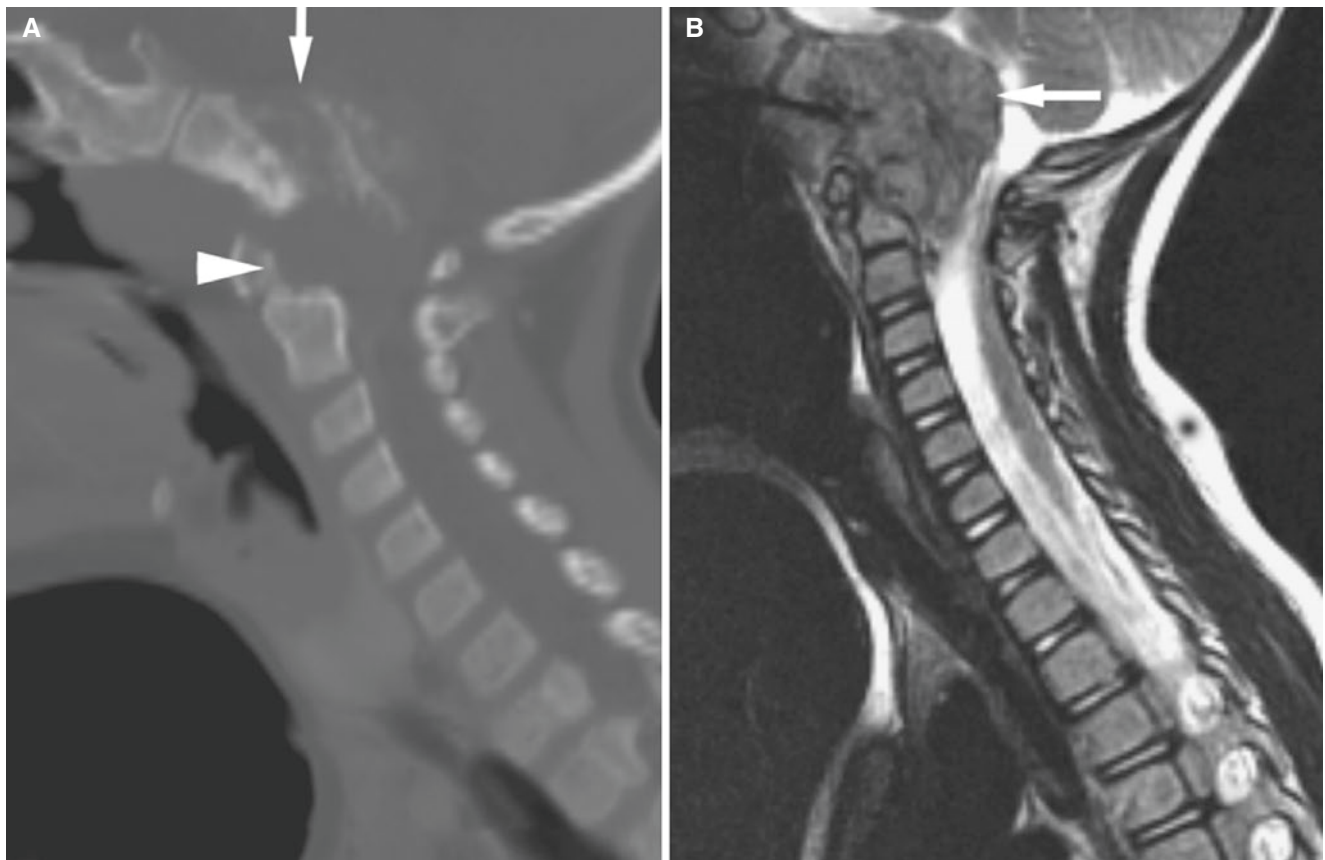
Chordoma at craniocervical junction; 3-year-old female with a history of anorexia and lethargy for 2 months, presenting with mild cervical spine pain. (A) Sagittal reconstructed CT image shows destruction and bone production in skull base (*arrow*) and C1 area. Top of dens is eroded (*arrowhead*). (B) Sagittal T2-weighted MRI shows a large hypointense expansile mass emanating from the clivus (*arrow*). (C) Sagittal T1-weighted post-Gd MRI demonstrates a slight enhancement
